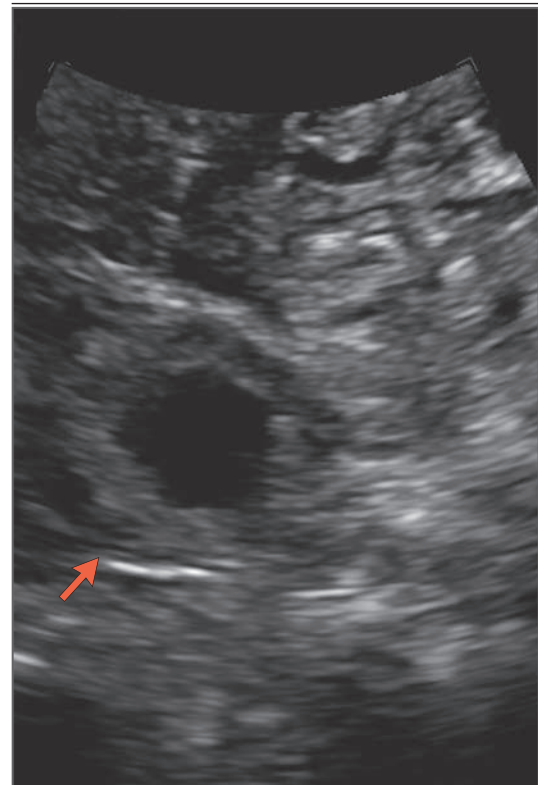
Transvaginal Ultrasonogram of Probable Tubal Ectopic Pregnancy.
